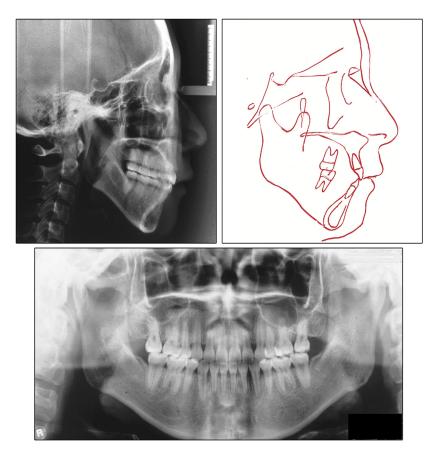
Posttreatment cephalograph, tracing, and panoramic radiograph.
